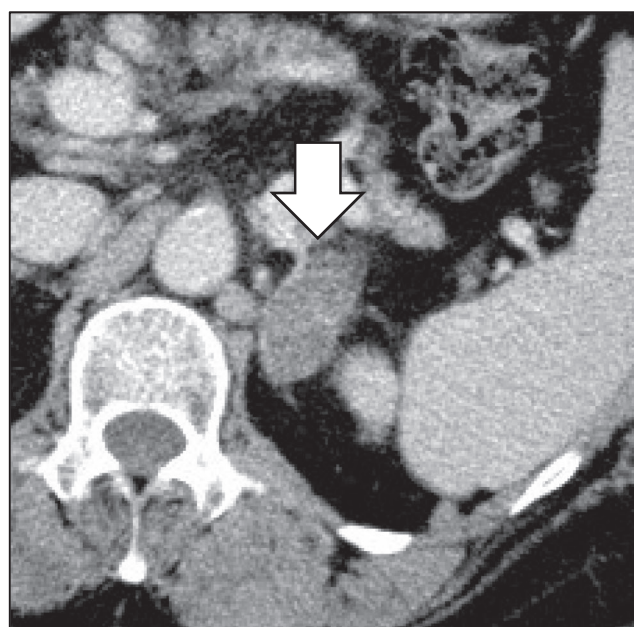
Contrast-enhanced CT examination. Contrast-enhanced CT examination revealed a tumor (arrow) with a major axis of about 30 mm in the left adrenal gland
